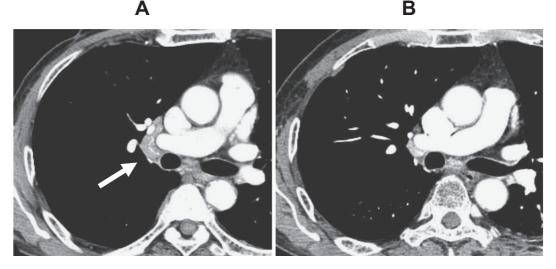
Chest computed tomography (CT) scan on admission (A) and after chemotherapy (B) in case 1. Chest CT scan showed a swollen lymph node in the right hilum before chemotherapy (arrow), and the lymphadenopathy disappeared after chemotherapy (B).
